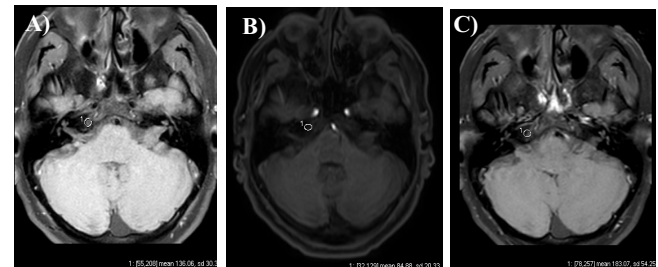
T1-weighted MR images with SPIR (A), mDixon (B) and SPAIR (C) techniques for fat suppression. (A higher resolution / colour version of this figure is available in the electronic copy of the article).
